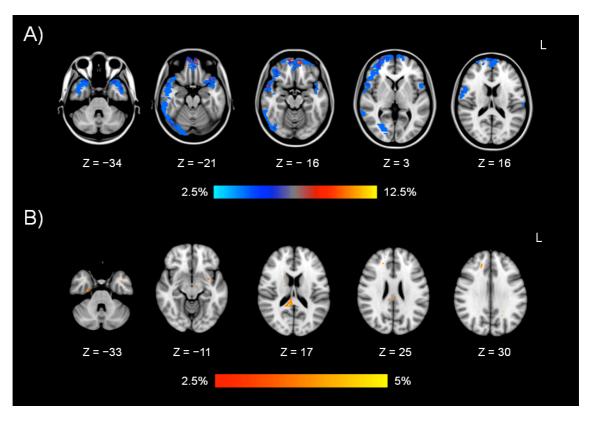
Lesion distribution and probability. Percentages of the 40 patients showing MRI evidence of A) brain contusions and B) white matter lesions.
